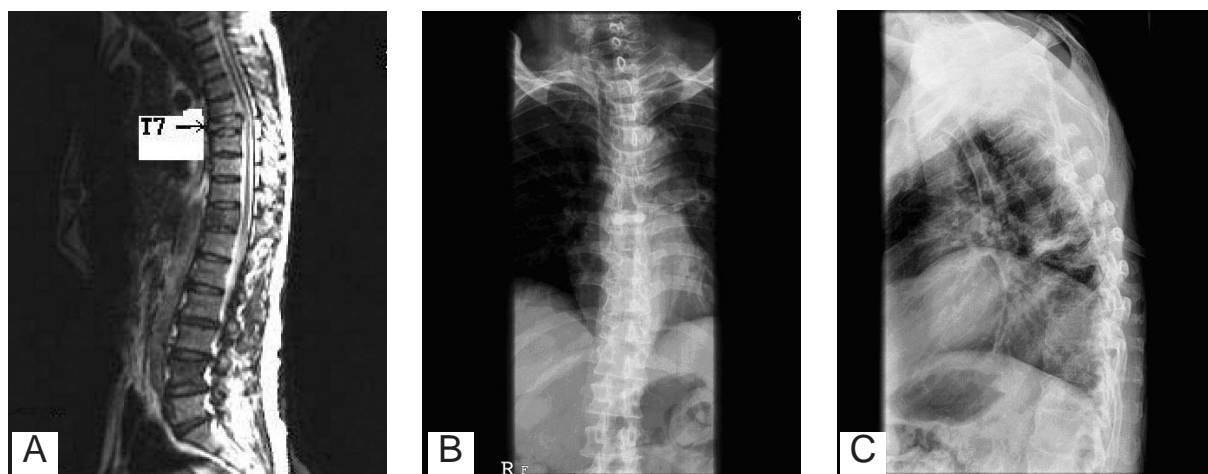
An metastatic tumor with compression fracture in the T7 body and compression of the cord are evident in this T1-weighted magnetic resonance (MR) image. B, C: The polymethylmethacrylate (PMMA) cement in the T7 vertebral body is evident on this T-spine X-ray.
